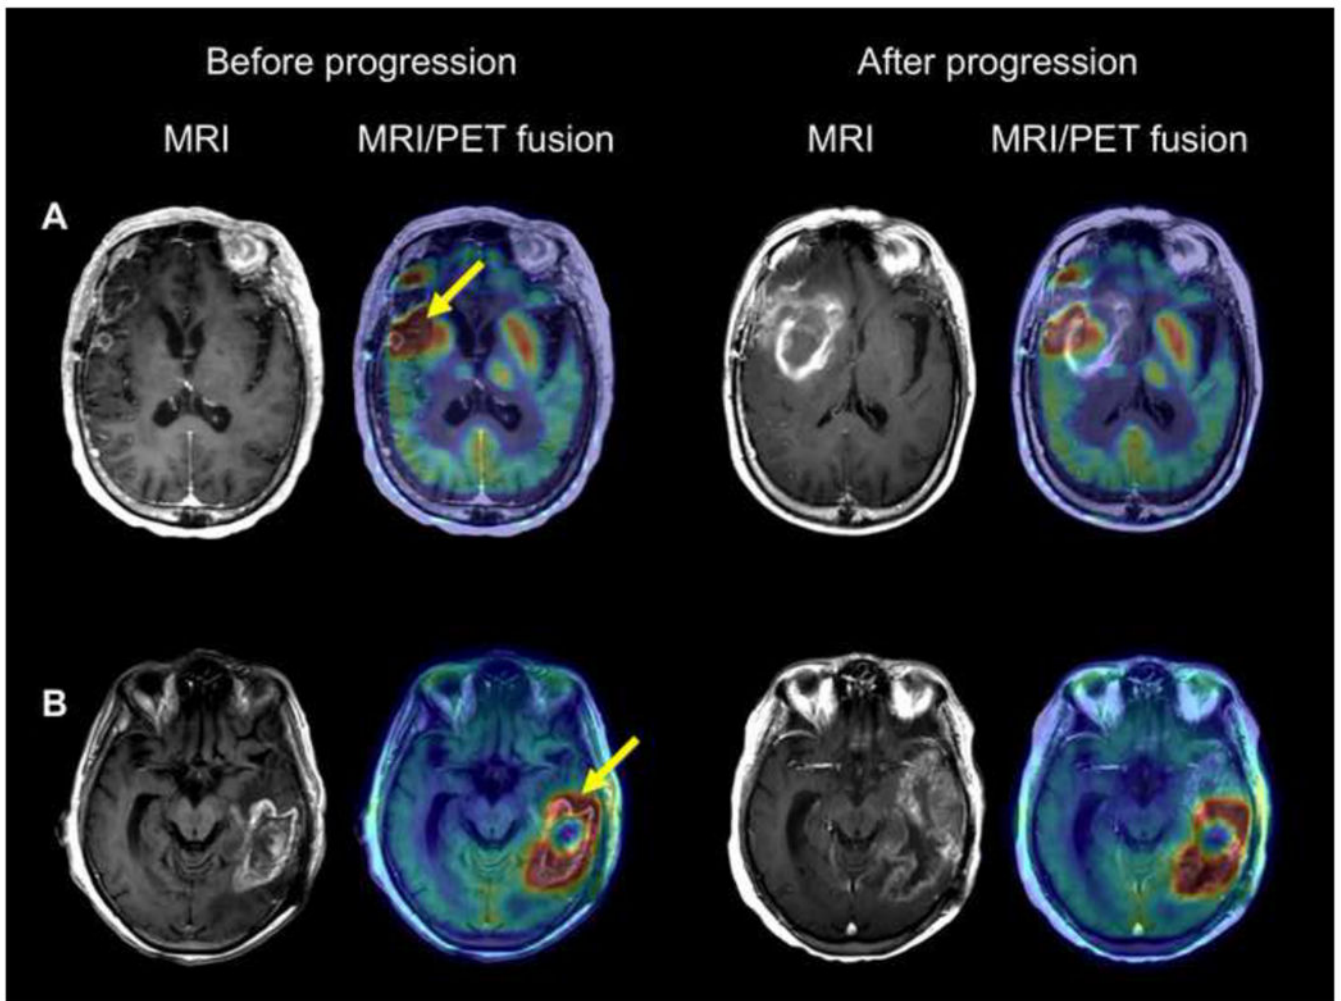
T1-Gad MRI and co-registered MRI/AMT-PET fusion images of two patients with tumor progression beyond the PET+ region
